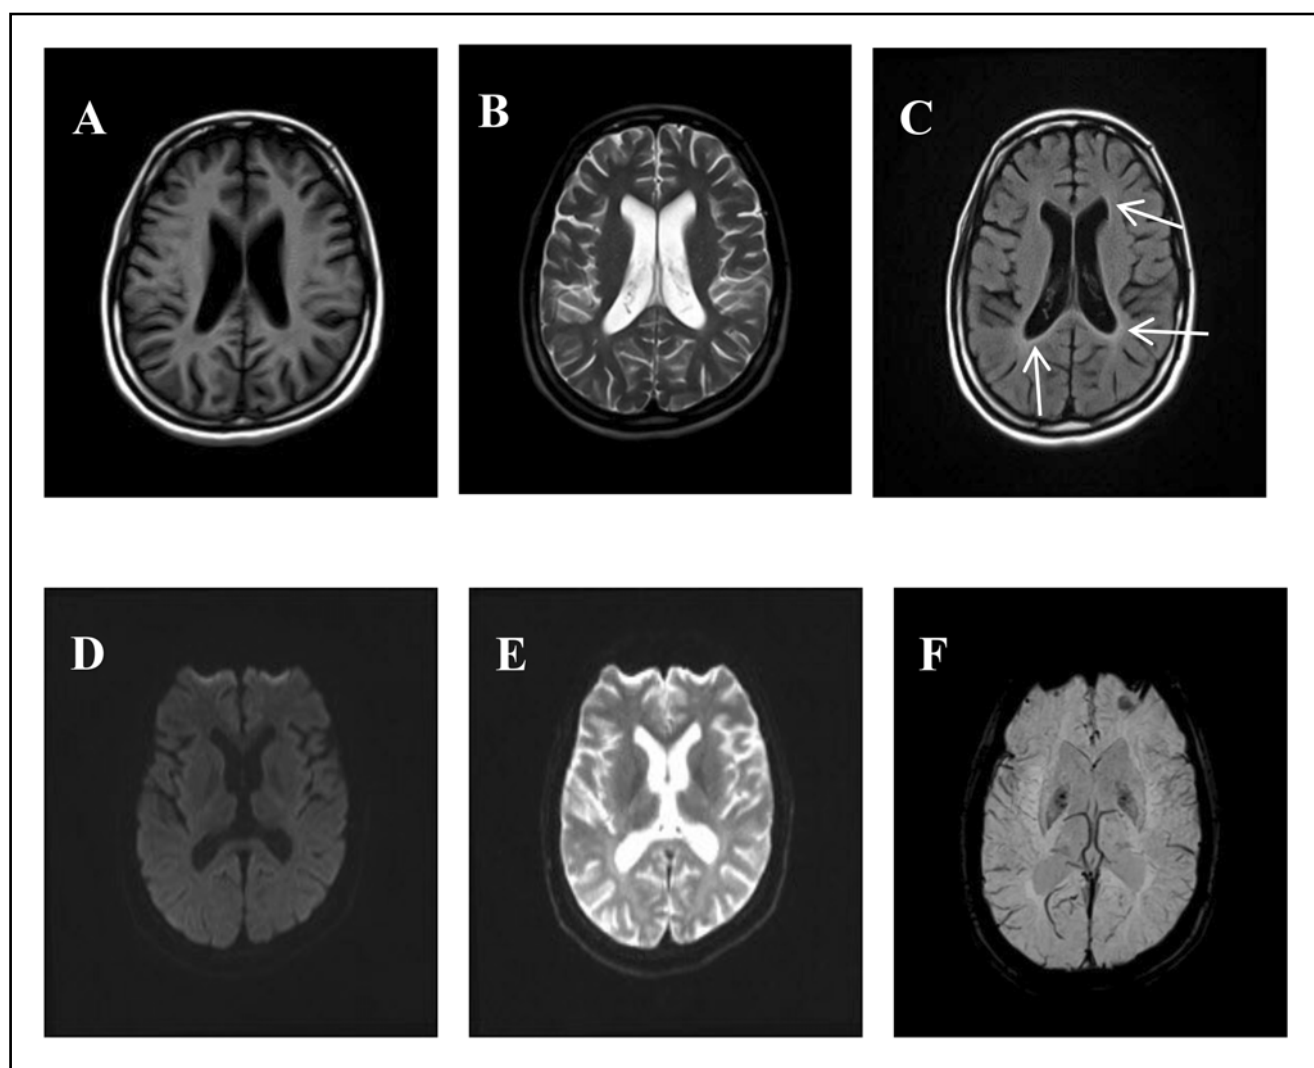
MRI scan of the patient's brain
